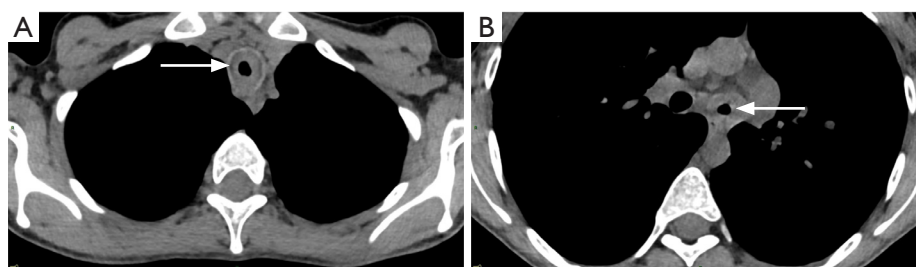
Thoracic CT scan, transverse section, non-injected, mediastinal window. (A) Circumferential thickening of tracheal wall, responsible for tracheal stenosis (arrow). (B) Circumferential thickening of main left bronchus wall, responsible for bronchial stenosis (arrow). CT, computed tomography.
